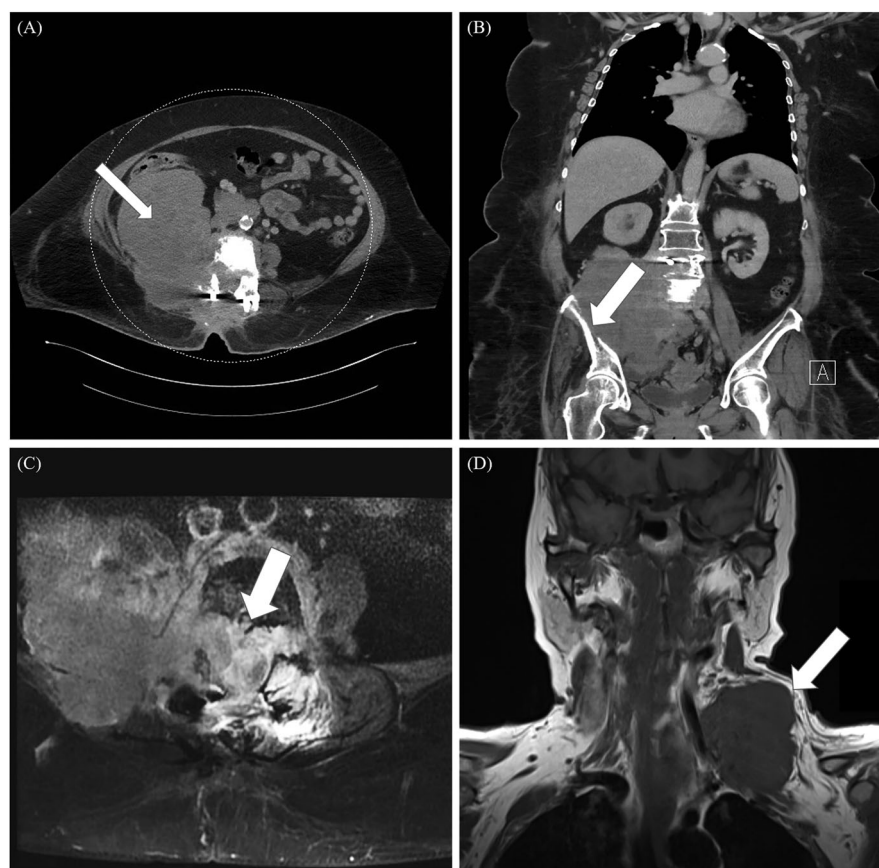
Contrast-enhanced computer tomographic (CT) (panel A: transverse view; panel B: coronal view) and contrast-enhanced T1-weighted magnetic resonance (MR) scans of the patient (panel C: axial view of lumbar spine, showing occupied the right iliac fossa by the solid intra-canal tumor; panel D: coronal view of neck).
